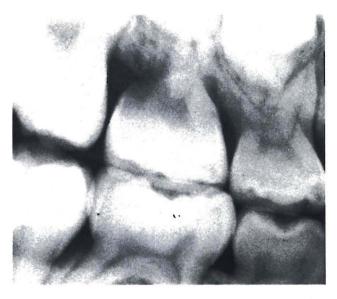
Six-month posttreatment radiograph. The condition is corrected.
